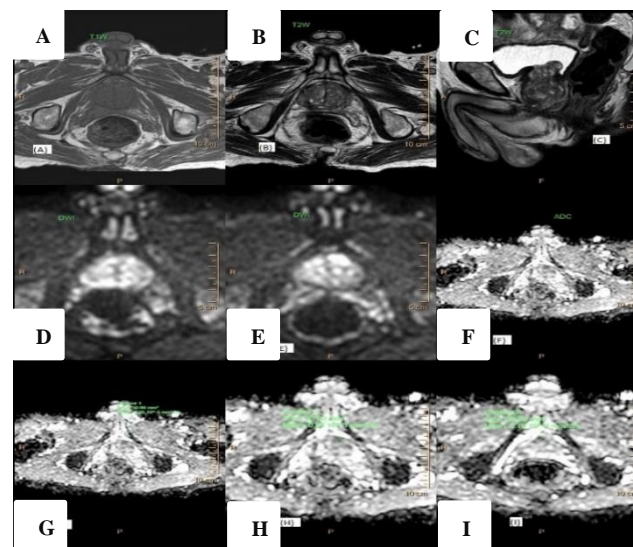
Patient of chronic prostatitis with BPH, (A) Hypo-intensity on T1Wi, (B, C) Multiple areas of T2 hypointensity in the background of organized chaos, (D, E) On DWI Mild to moderate diffusion restriction, (F to I) Corresponding low ADC values.
